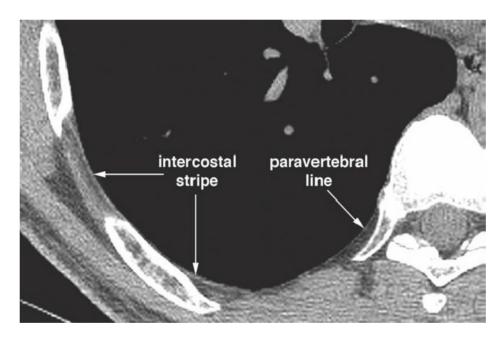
On HRCT in a normal subject, thin white line which represents the intercostal stripe and paravertebral line
